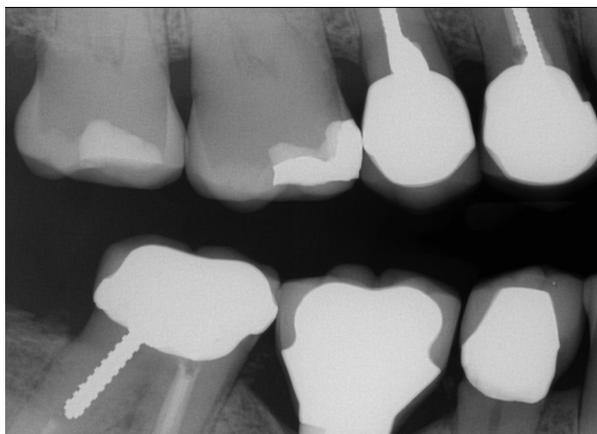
Radiograph showing open contact still present at tooth no. 30 mesial (November 4, 2014), but now there is extensive caries on distal aspect of tooth no. 29, which precipitated the need for a full-coverage restoration on tooth no. 29.
